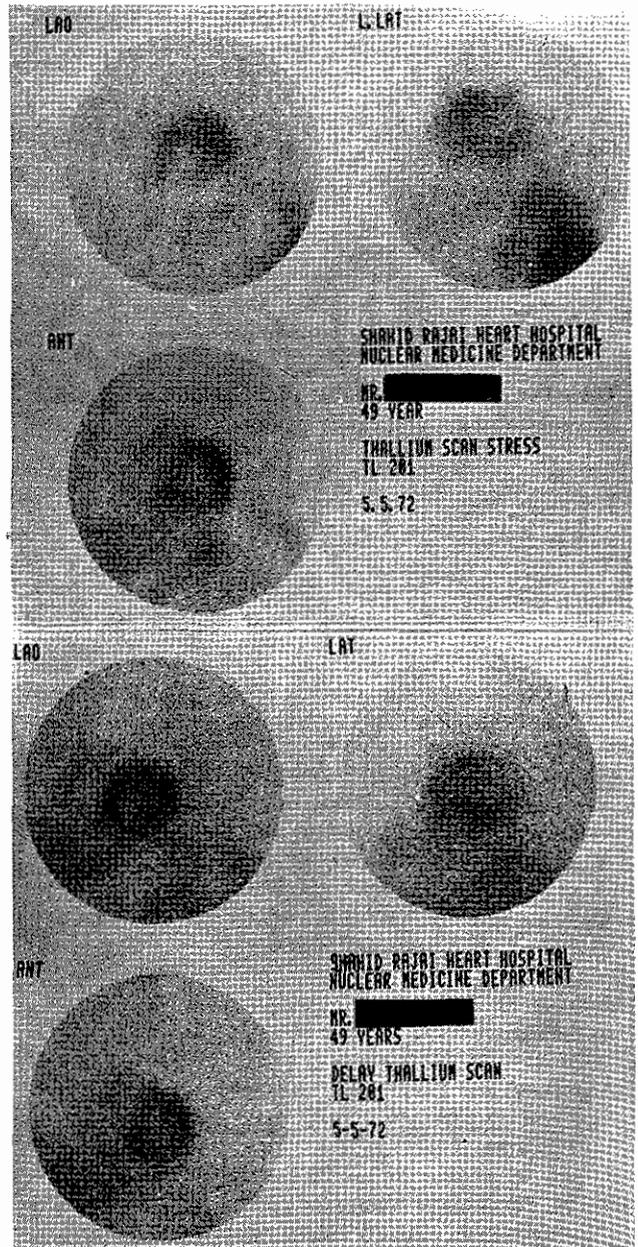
Initial (left images) stress and 4-hour delayed (right images) planed thallium scintigram showing reversible perfusion defects involving the inferior wall and apex in a 49 year old man. Coronary angiogram (not shown) revealed a significant stenosis in the middle portion of RCA.
